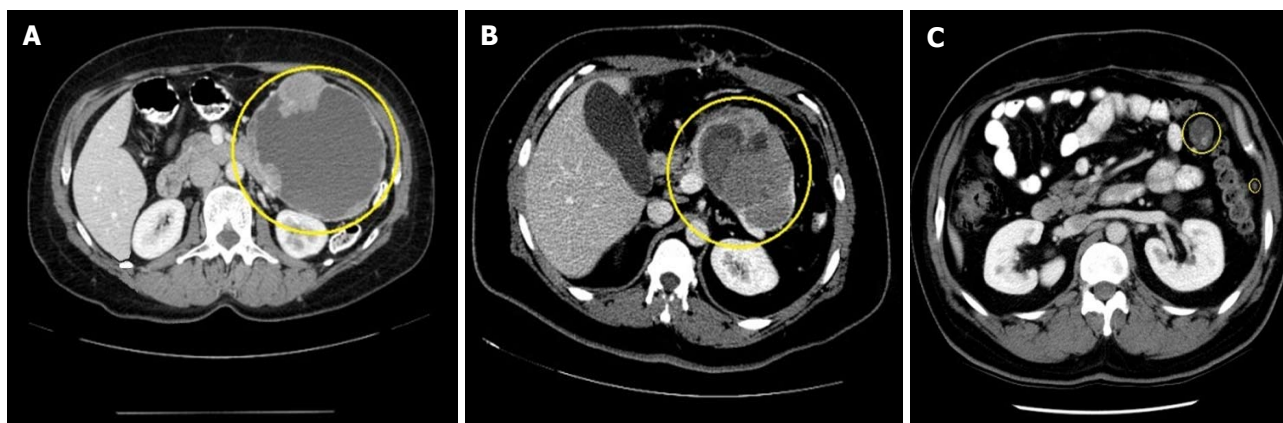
Computed tomography appearances. A: A pancreatic tail solid pseudopapillary neoplasm. Note the characteristic enhancing solid spaces at the periphery of an encapsulated SPN, accompanied by centrally located cystic space; B: Pancreatic tail solid pseudopapillary neoplasm with septation. The cystic component of SPN with degeneration is characterized by a heterogeneous hypoattenuation on CT; C: Abdominal metastatic lesions of SPN. SPN: Solid pseudopapillary neoplasm; CT: Computed tomography.
